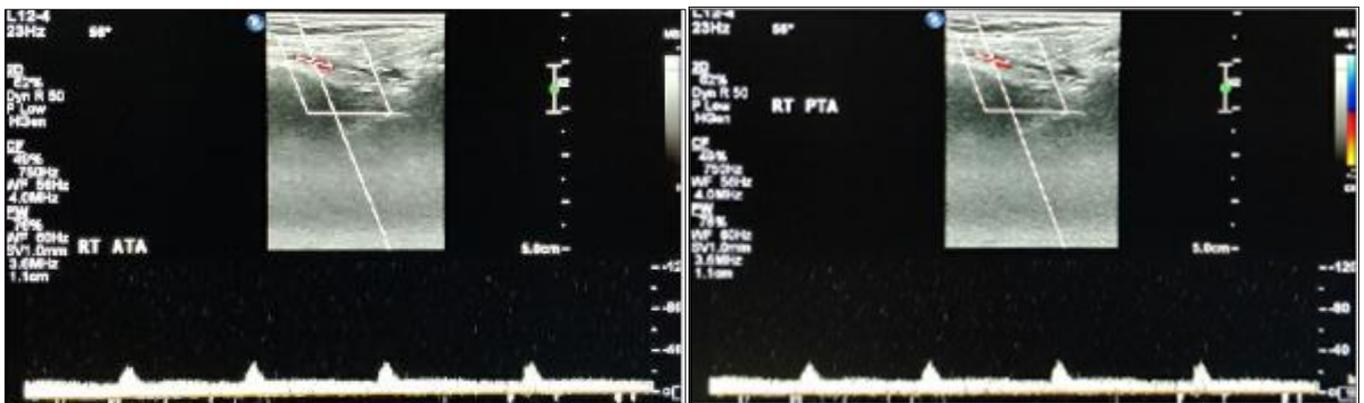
Longitudinal Color Doppler image showing low velocity, dampened monophasic altered waveform in right anterior and posterior tibial arteries. Findings were suggestive of hemodynamically significant stenosis (Grade3 or 4) in proximal arterial segment.
